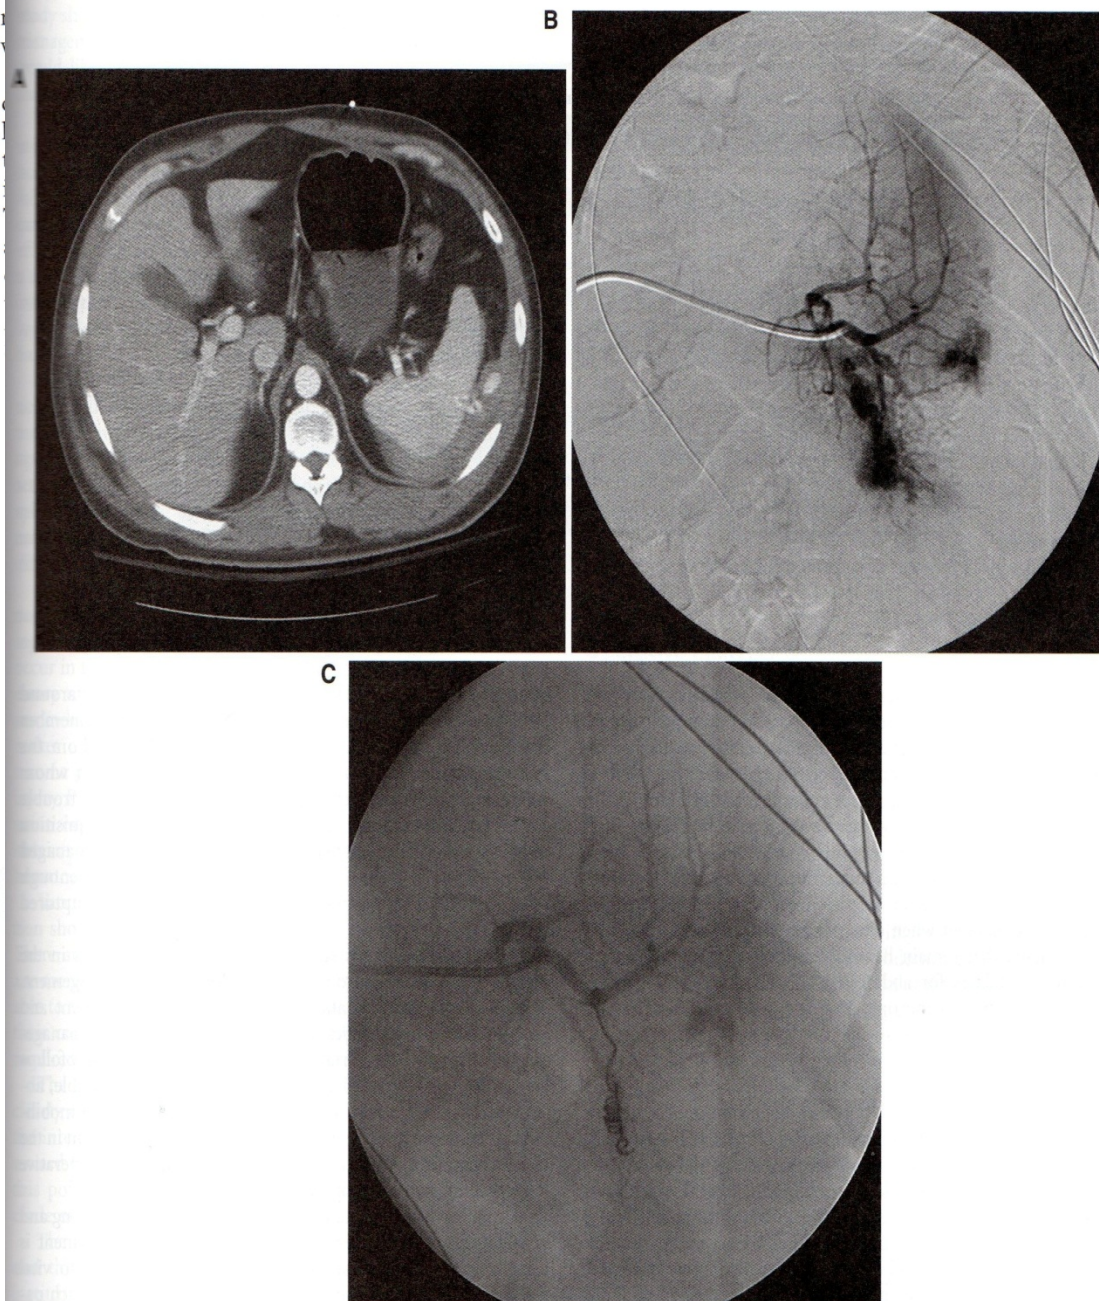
Computed tomography findings in blunt splenic injury, grade IV. A laceration through the parenchyma of the spleen with disruption of the capsule.
